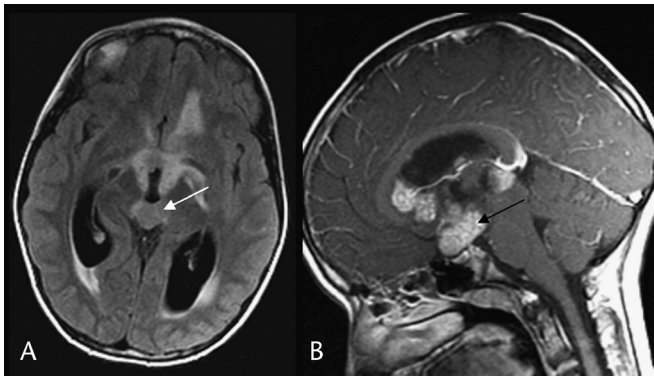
Multicentric, mixed germ cell tumor. Axial FLAIR (A) and sagittal gadolinium T1 (B) images show optic-hypothalamic (black arrow), pineal (white arrow), and bilateral periventricular isointense/hyperintense and enhancing nodular masses and HC with periventricular edema.
